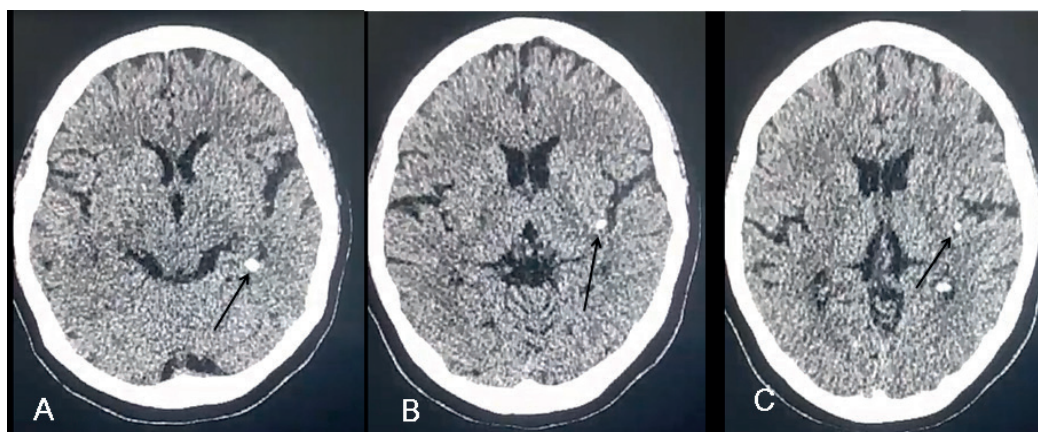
CT scan of the head, axial sections, brain parenchyma window. Small hyperdense images, calcific density in the left cerebral hemisphere in relation to calcifications (arrows)
